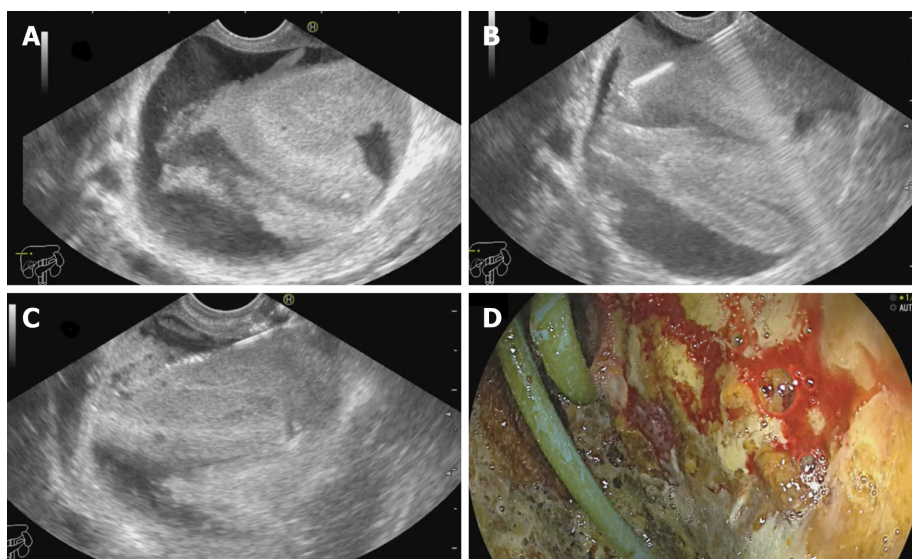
Endoscopic ultrasound-guided drainage of biloma. A: Post-operative biloma noted on endoscopic ultrasound (EUS) with internal echoes; B: EUS-guided puncture of the biloma; C: Guidewire negotiated into the collection followed by placement of naso-cystic drain; D: Endoscopic view of the cavity entered with catheter noted *in situ*.
